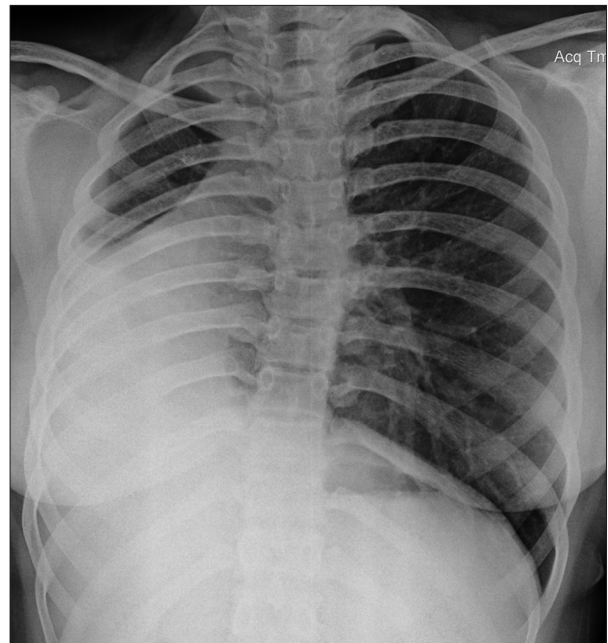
X-ray chest PA view. A homogeneous opacity in the right middle and lower zone with shift of the mediastinum to the right side along with scoliosis.
